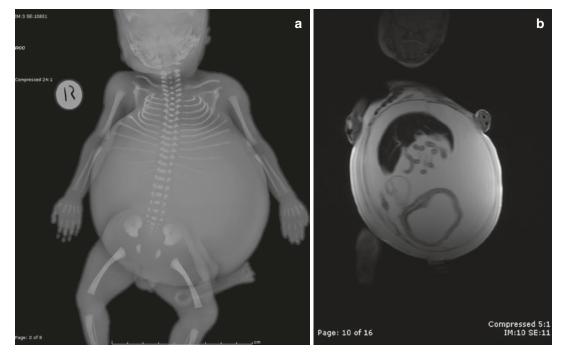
(a) Postmortem X-ray of same foetus as shown in Fig. 67.1 after termination. The massively enlarged abdomen is obvious. (b) Postmortem MRI of same foetus
